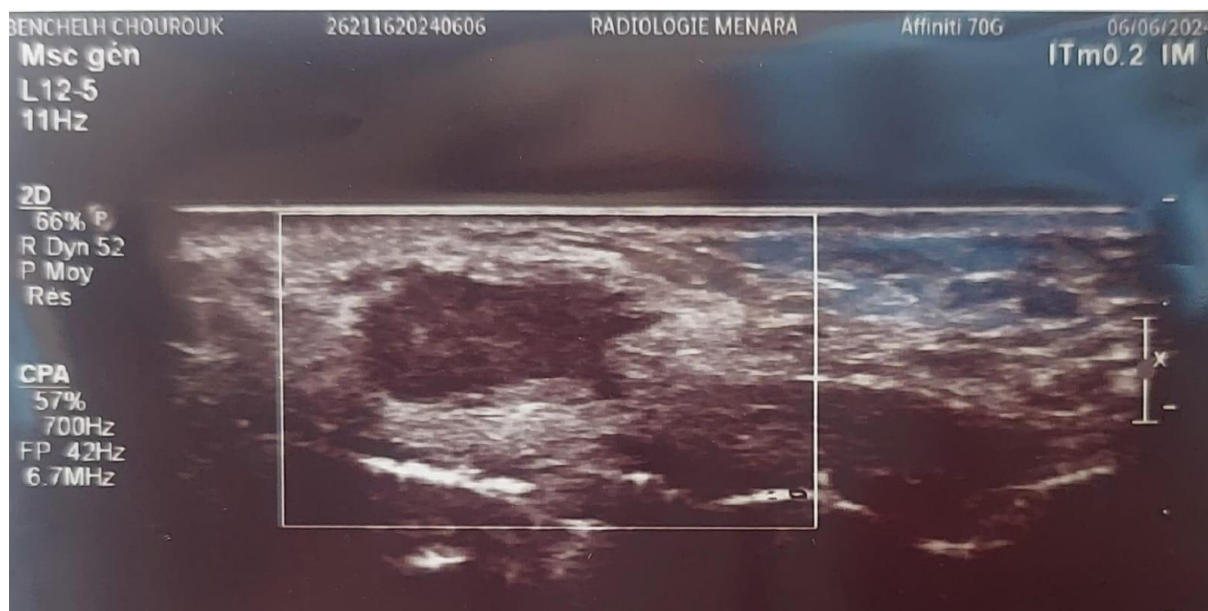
Soft tissue ultrasound showing an oval-shaped lesion measuring 4.4×11 mm, with well-defined margins and a homogeneous hypoechoic echotexture, without detectable vascularization
